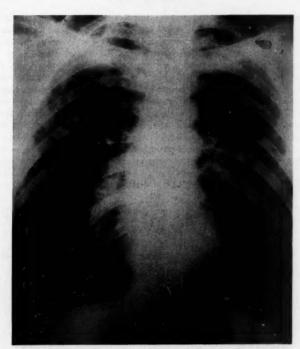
Appearance of the chest of case 1 by x-ray examination during the first admission, October, 1958. Note microcardia and the diffuse infiltration in both lung fields.
